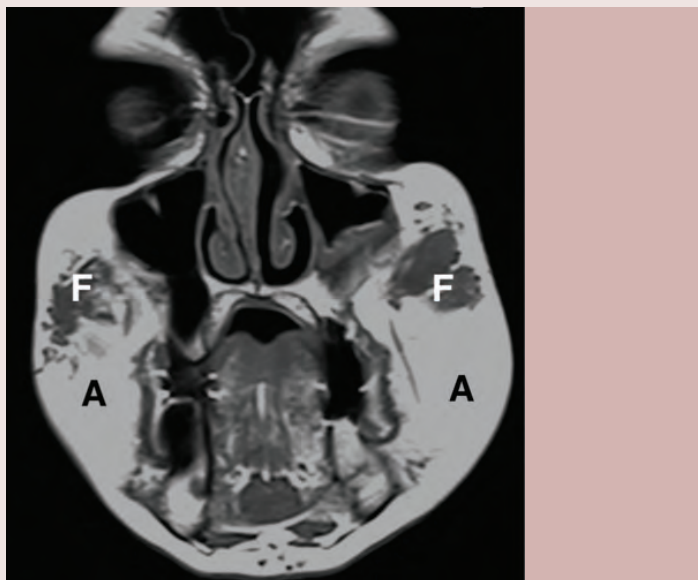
MRI T1 coronal. Increased fat (A) bilaterally. Filler (F) also present bilaterally.
